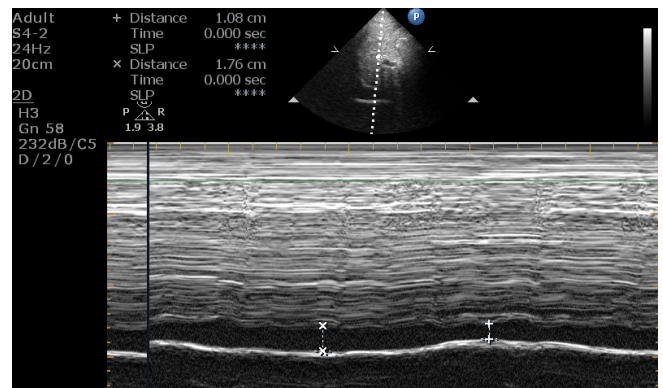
Ultrasound image of IVC diameter during inspiration and expiration
